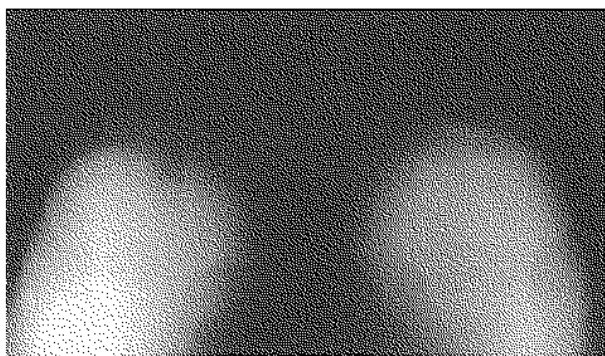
(a-b). — Radiographic axial view. Note the different distance between the femoral groove, and the anterior tibial border of the injured right knee, on the left compared with the contralateral healthy side, on the right.
